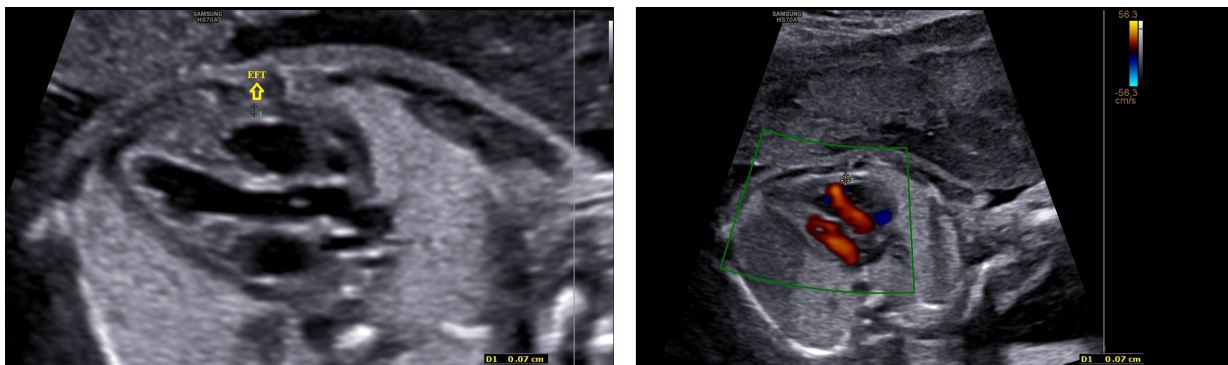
Standardized epicardial fat tissue (EFT) thickness measurement via left ventricular outflow tract (LVOT) view was applied to differentiate it from pericardial fluid by Doppler sonography.
